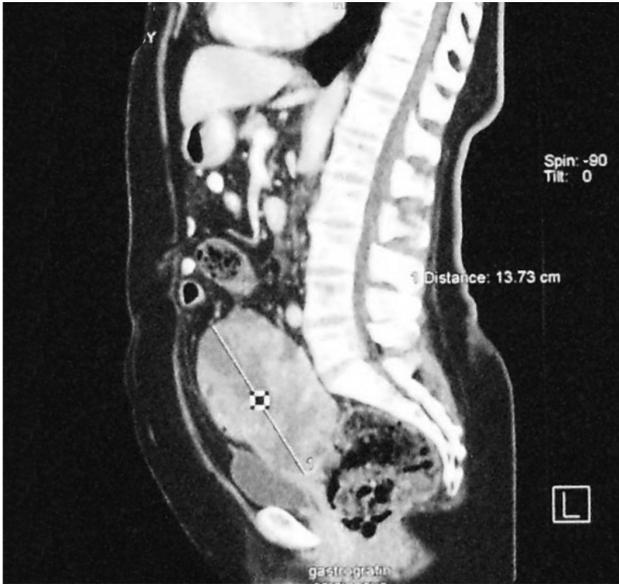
Preoperative abdominal/pelvic computed tomography imaging revealed a large (14 cm), encapsulated tumor originating from left ovary.
